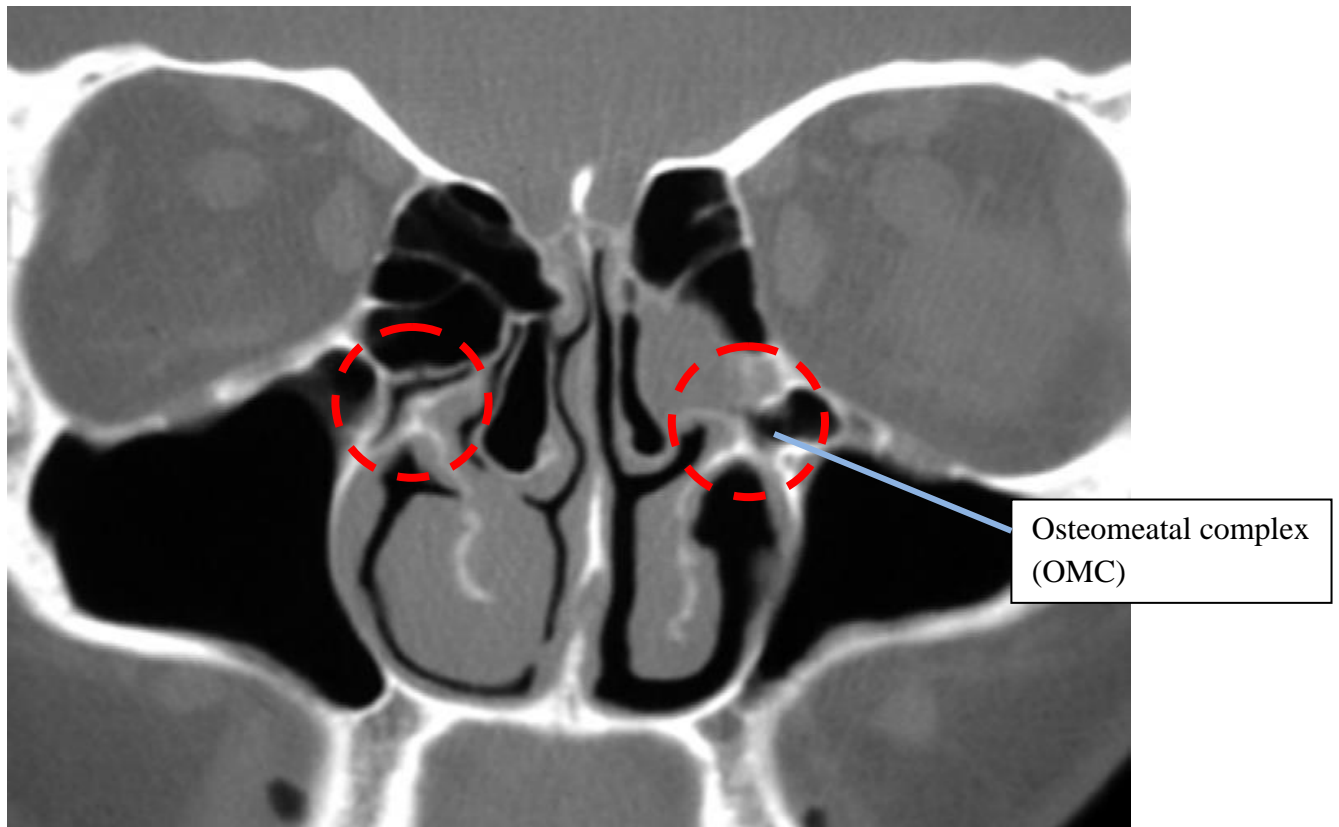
CT scan PNS (coronal view) showing osteomeatal complex and paranasal sinus (adopted from James NP *et al* 2013)
